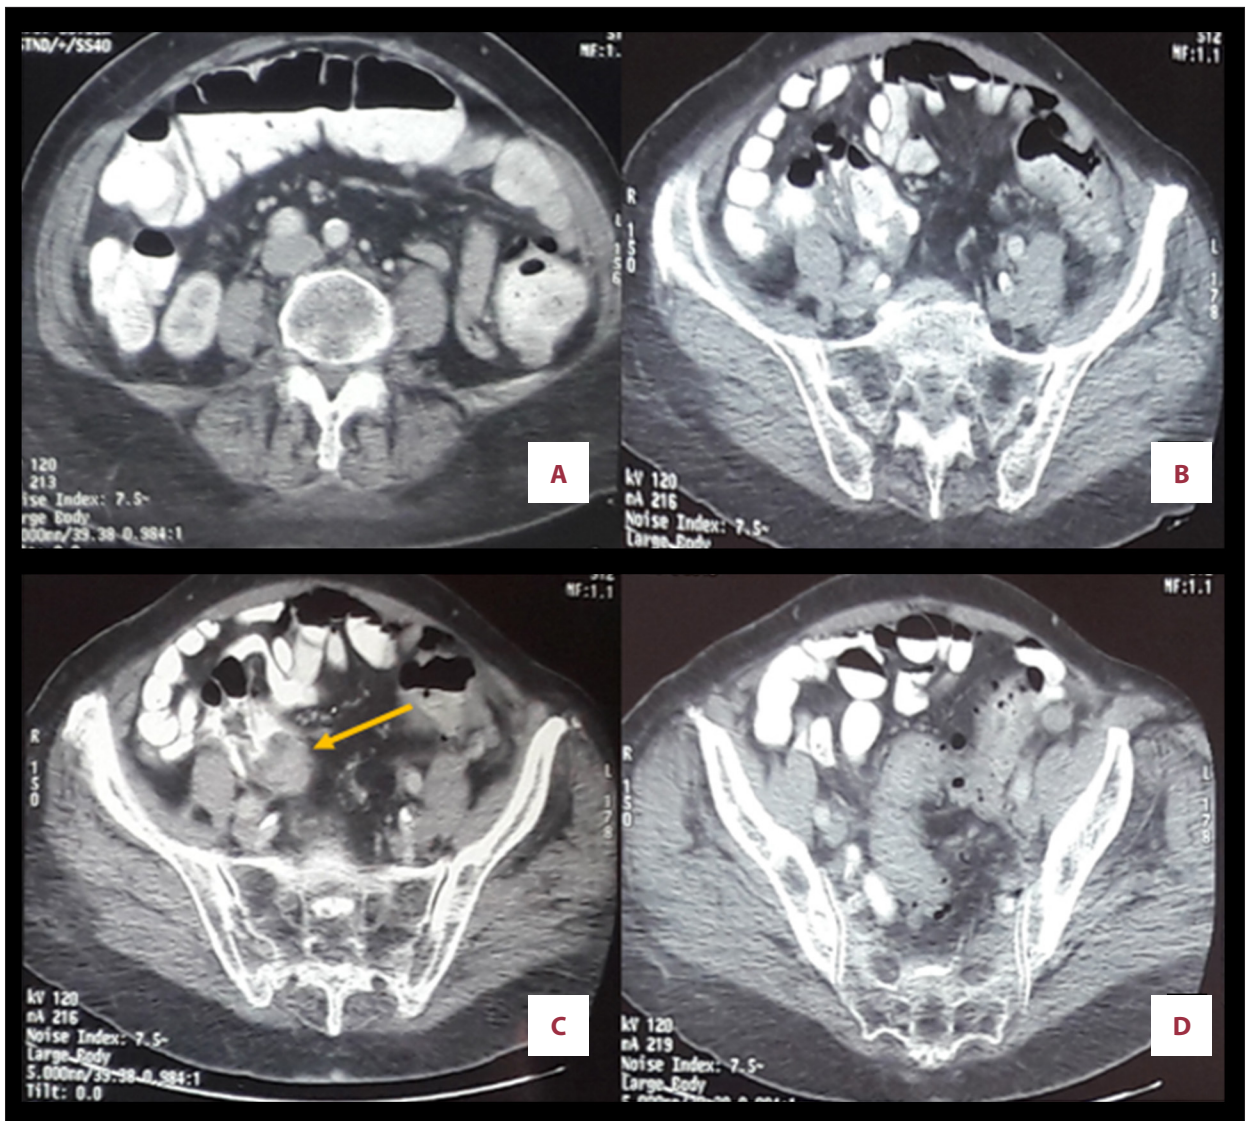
Computed tomography scan after deterioration of clinical status (A, B, D) large bowel obstruction due to diverticulitis of the sigmoid colon (C) filling defect in the cecum (arrow).
